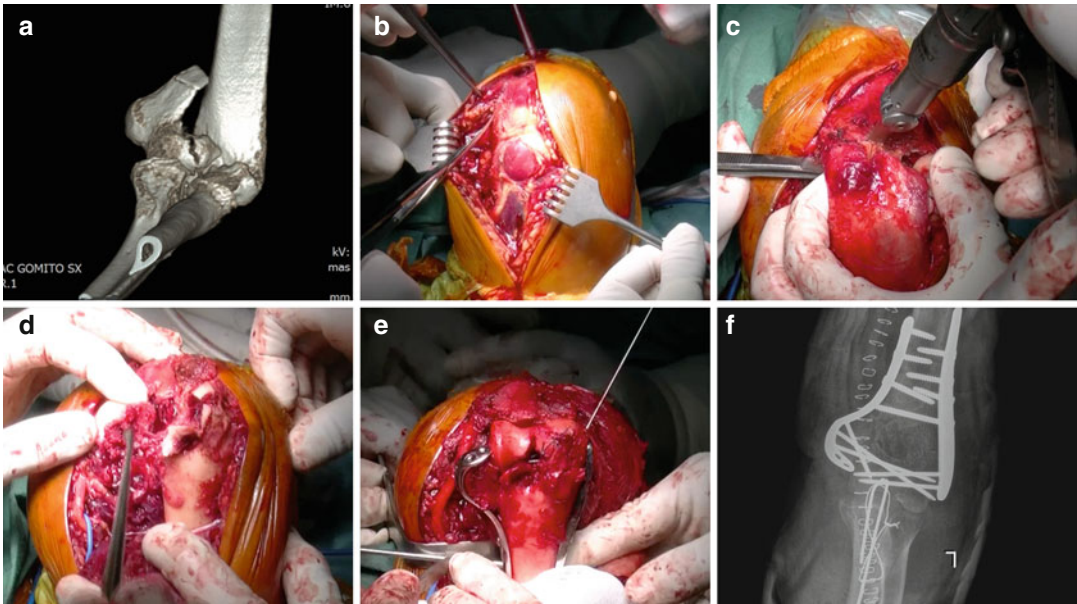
A transolecranon osteotomy used to fix a fracture with comminution of the articular surface. (a) 3D CT scan showing the comminution of the trochlea. (b) Posterior approach to the elbow with two deep flaps that
